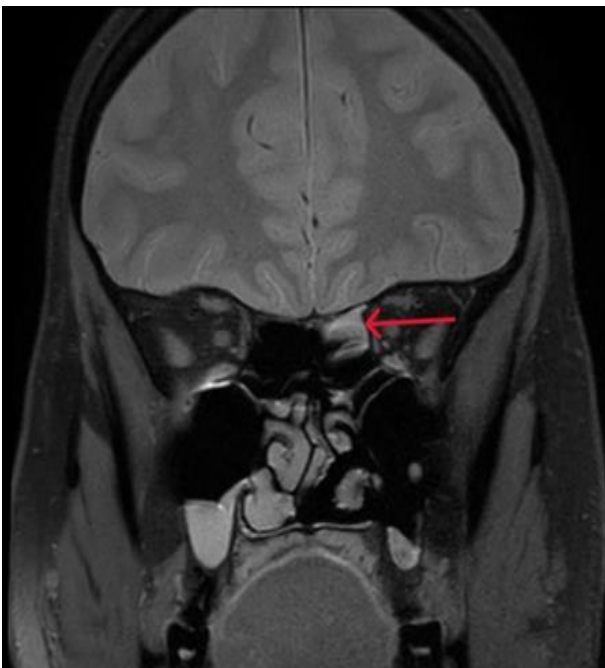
Coronal view of MRI brain showing CSF in left sphenoid sinus.
